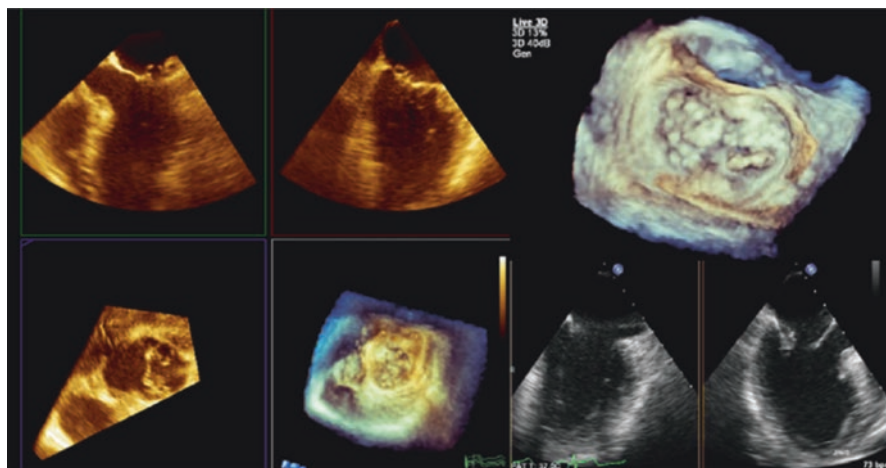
Three-dimensional echocardiography assessment of a patient with severe mitral regurgitation. With the full-volume 3D acquisition, offline analysis of the data set accurately identifies the posterior mitral leaflet medial flail segment (*left panel*). Real-time 3D acquisitions also visualize the posterior medial flail segment with an enface view of the mitral valve from the left atrium, similar to the surgeon's view of the mitral valve (*top right panel*). Simultaneous biplane imaging of the mitral valve allows the assessment of the flail segment in high temporal and spatial resolution, both in two-dimensional (2D) and in color Doppler modes (*bottom right panel*). The medial location of the flail segment near the commissure makes it challenging for percutaneous treatment
